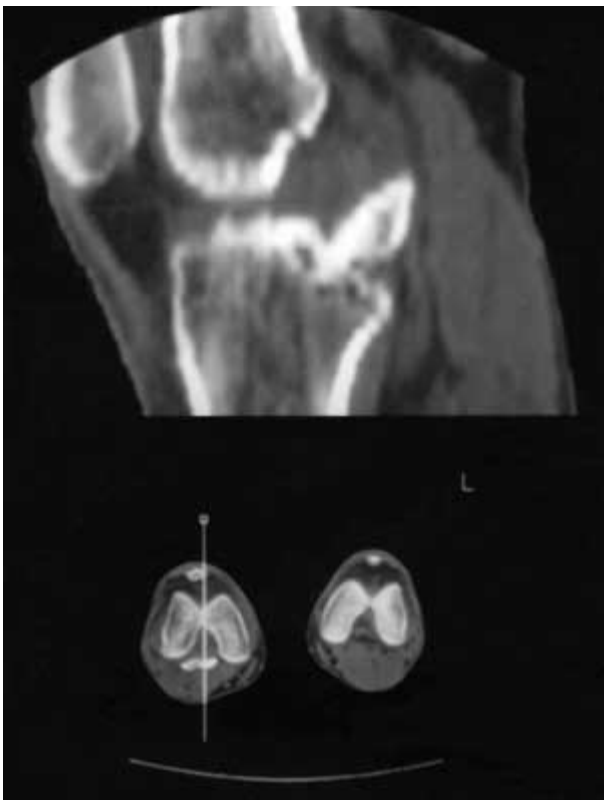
CT scan showing a large avulsed posterior fragment.
